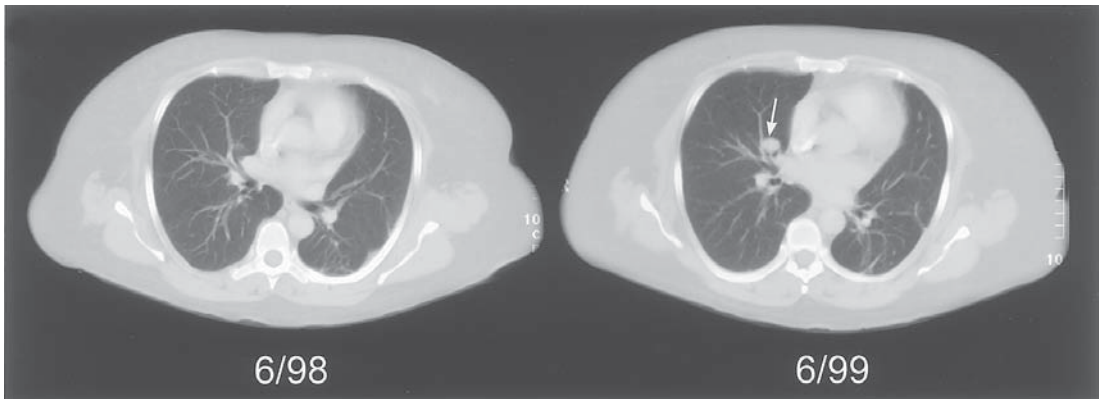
These chest CT scans demonstrate the development of a pulmonary metastasis in the medial segment of the right middle lobe [arrow]. The patient has undergone nephrectomy, 5FU and IL-2 therapy and previous pulmonary metastasectomy. The right middle-lobe nodule was successfully treated with right-middle lobectomy. Incidentally, at operation “silent” metastases not seen on chest CT scan were resected from the right upper lobe.
